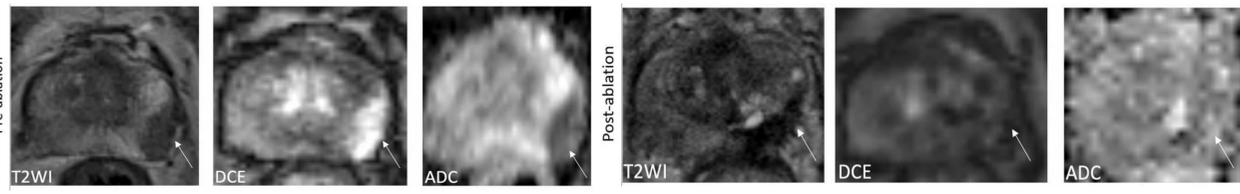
Example MRI study.
